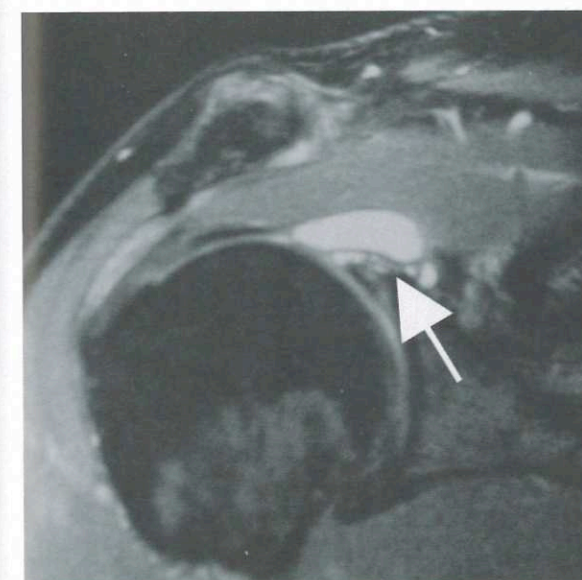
MRI coronal image with arrow highlighting a ganglion cyst that is associated with a SLAP lesion
